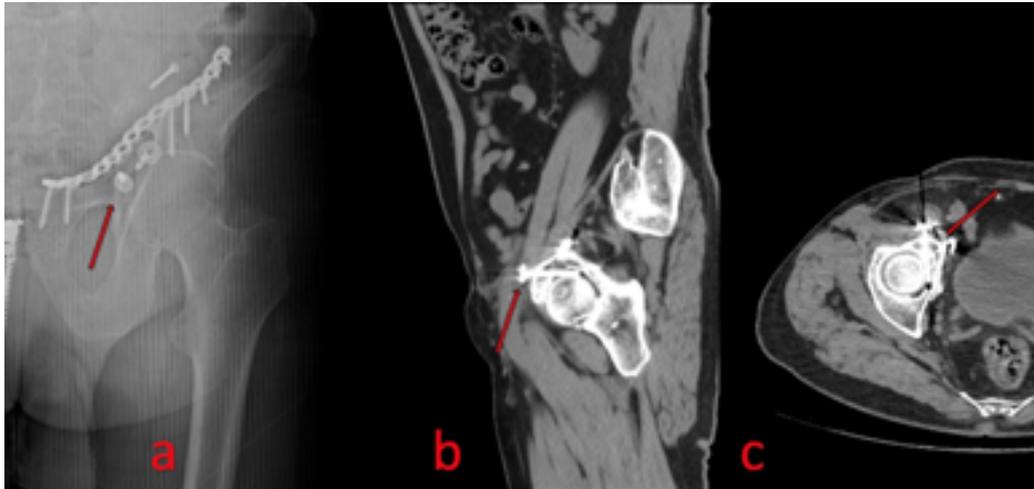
a) Preoperative pelvis anterior posterior (AP) X-ray shows the plate and free screws on the left ramus pubis and the screw that may extend into the femoroacetabular joint. b) Sagittal bone sequence computed tomography (CT) shows a screw in the joint and its location. c) Axial bone sequence CT shows the screws in the femoroacetabular joint.
